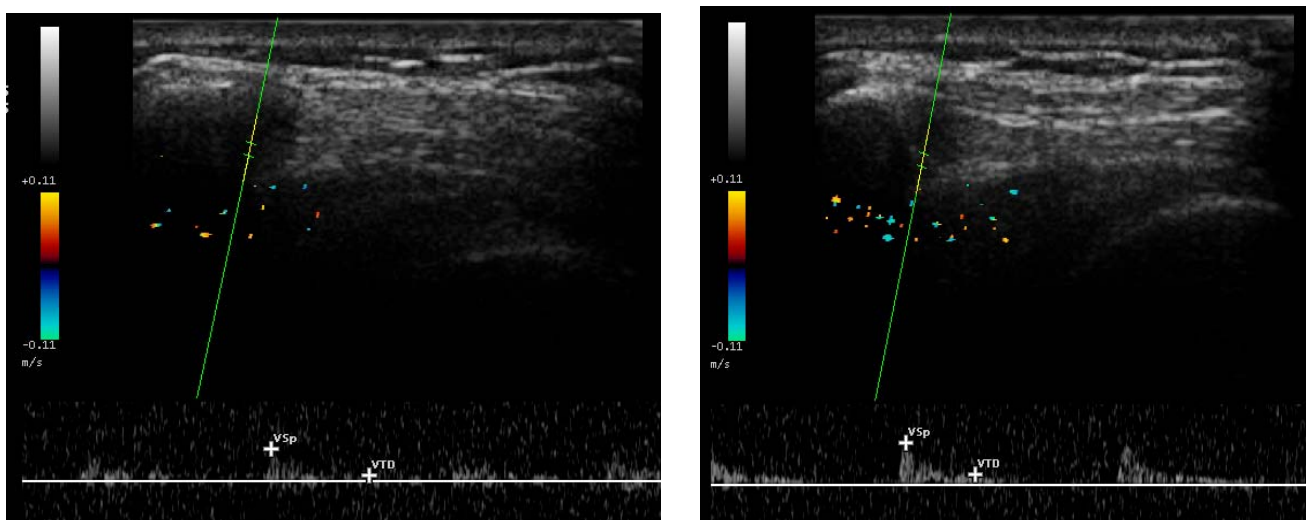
Functional Echomyography using color Doppler shows that the perfusion in the denervated muscle changes characteristics during stimulation, from pathognomonic low resistivity index and diastolic perfusion to higher index, implying increase of the blood flow.
